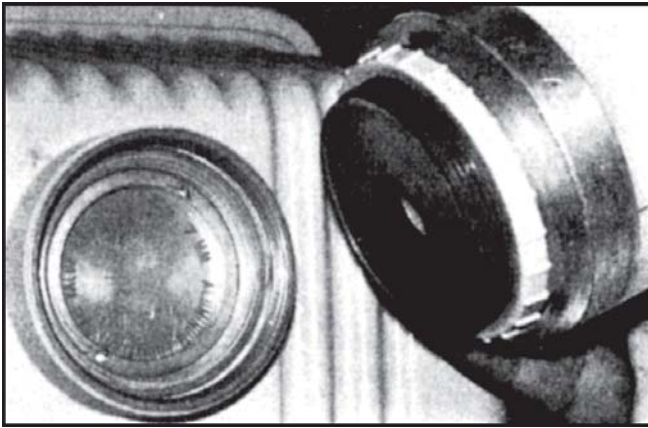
Aluminum disk in the X-ray tube head
